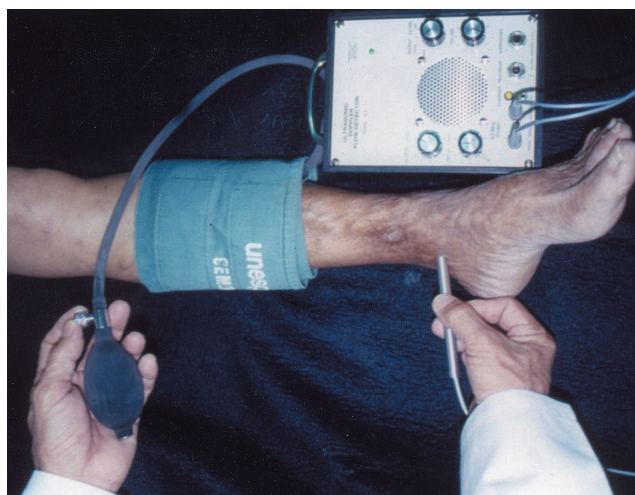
Technique to measure the ankle-arm index using a portable Doppler ultrasound
